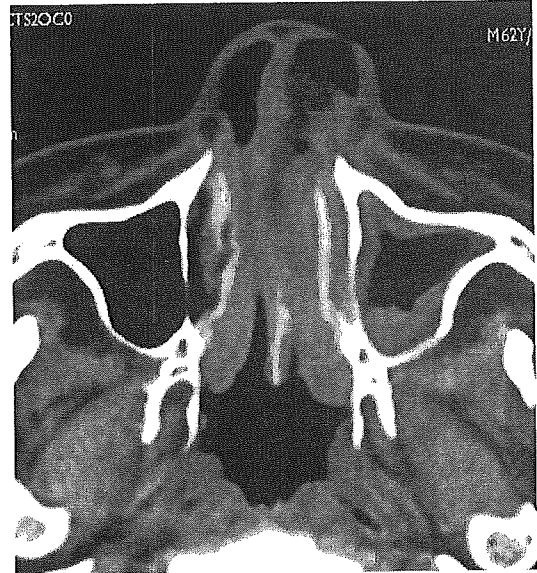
Computed tomography taken before treatment of Case 2. The tumor can be detected in the patient's nasal and paranasal cavities.
